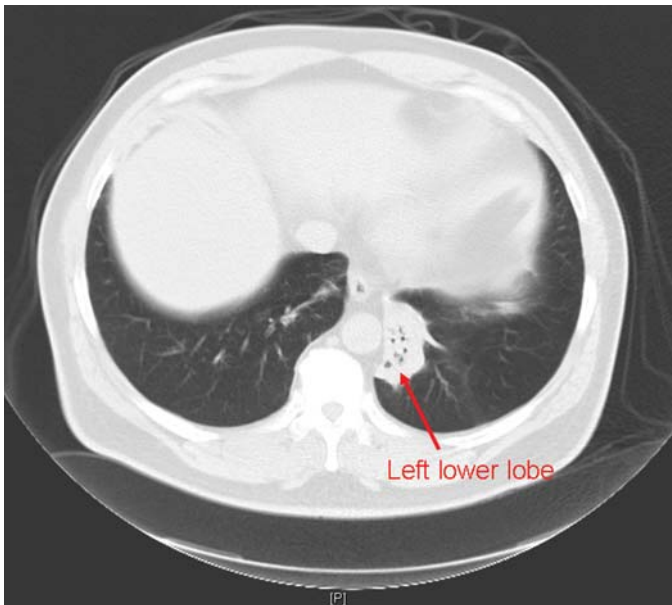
FIGURE e24-4 CT scan revealing chronic left lower lobe collapse. Note dramatic volume loss with minimal aeration. There is subtle mediastinal shift to the left.
